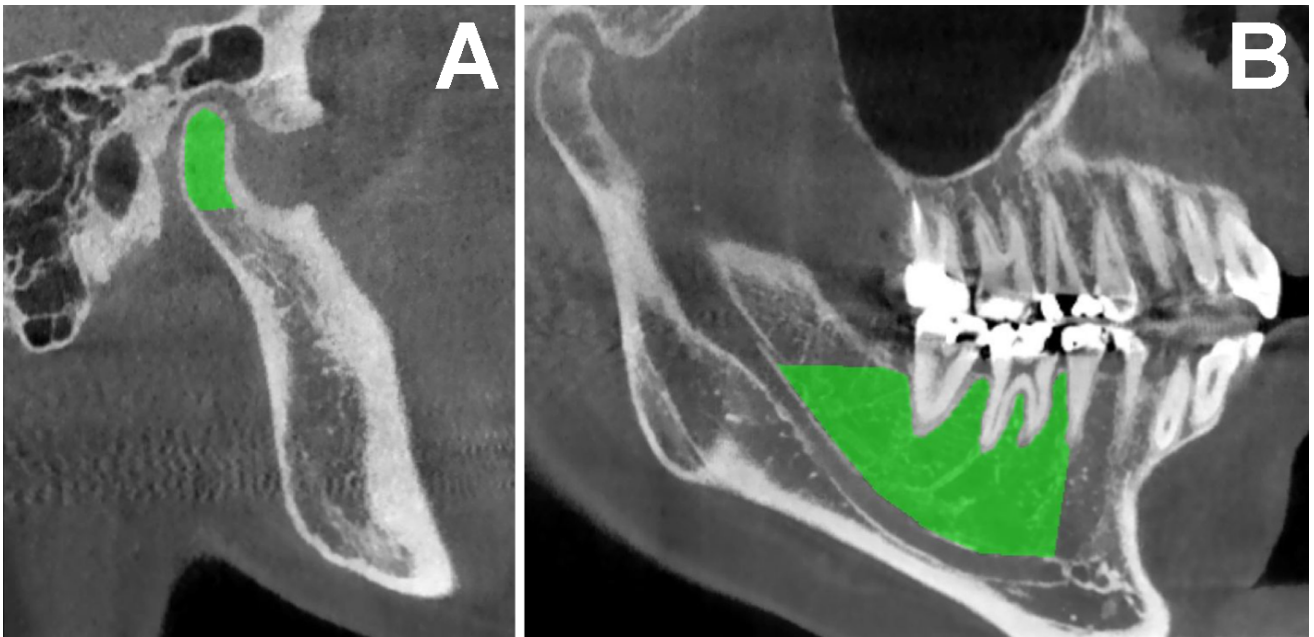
Areas of interest (in green) used to measure bone texture of condylar bone (A) and alveolar bone (B) on 2D sections of the mandible obtained by cone-beam computed tomography.
